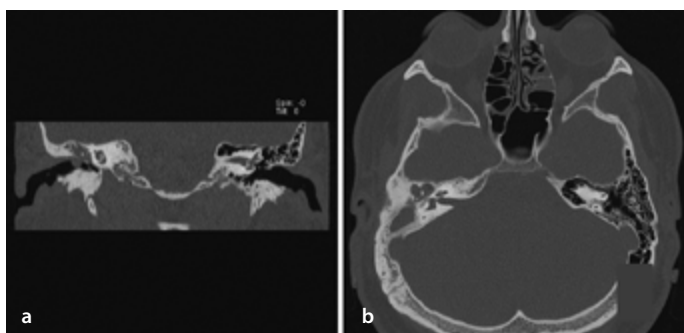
a, b. Coronal CT scan showing Prussak's space occupation with slight erosion of the ossicles and conservation of the scutum (a). Axial CT scan showing epitympanum and antrum occupation and erosion of ossicles heads. Mastoid cells were occupied (not shown here) (b)
